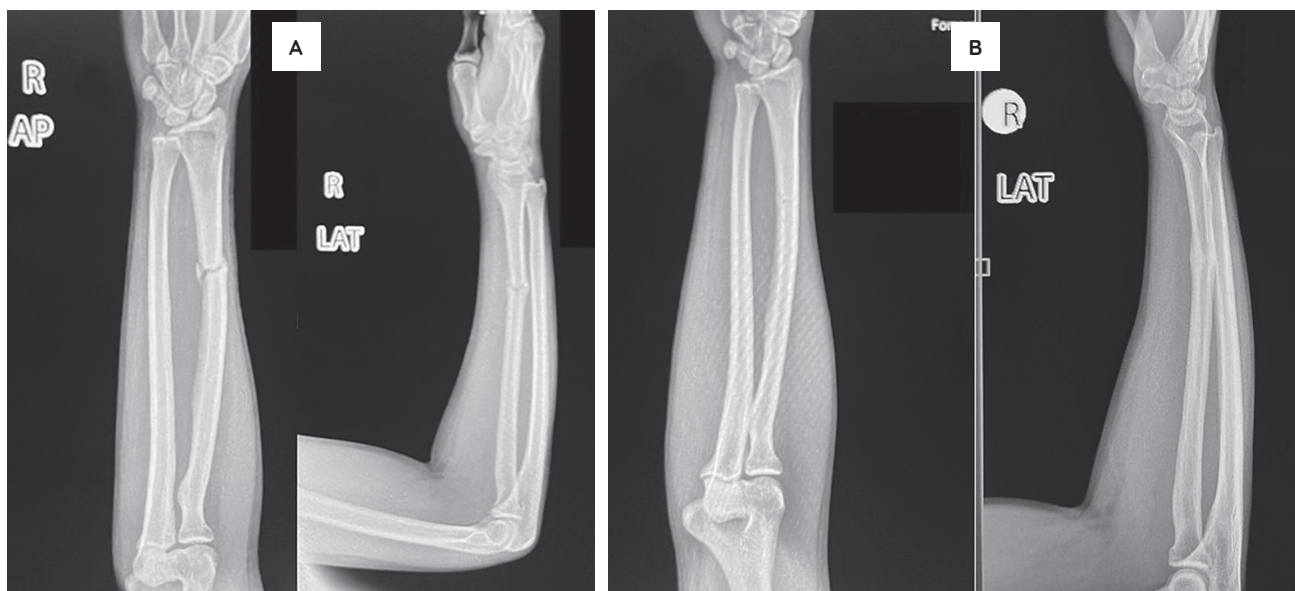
A 25-year-old male diagnosed with atrophic nonunion of the distal third radius after 7 months of conservative management with cast immobilization. Pre-PRP Radiograph (A) reveals no callus formation. Post-PRP Radiograph after 5 months (B) reveals absence of fracture line and recanalization.
